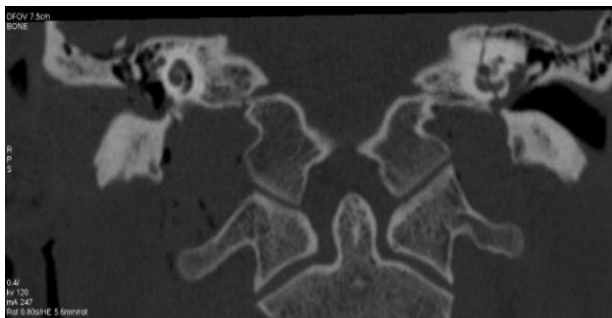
Coronal CT showing fracture line through the left cochlea.
